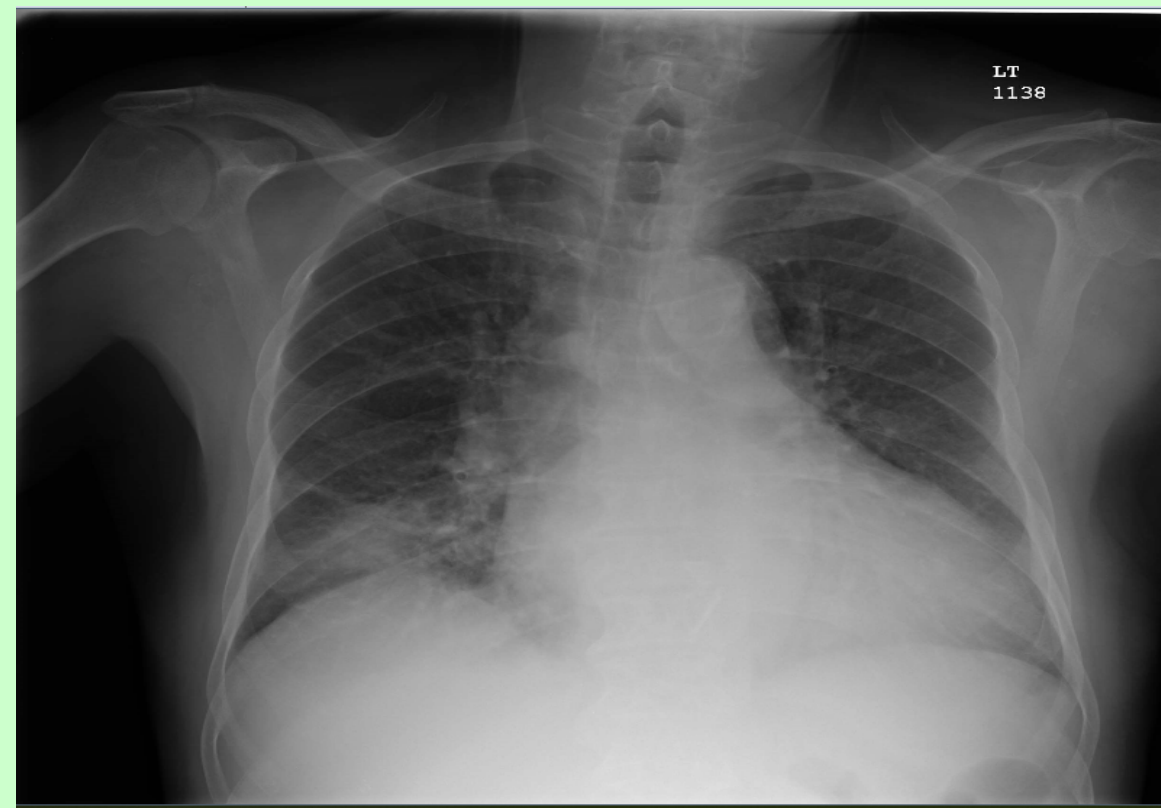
Chest radiograph from first admission showing a right lung infiltrate
